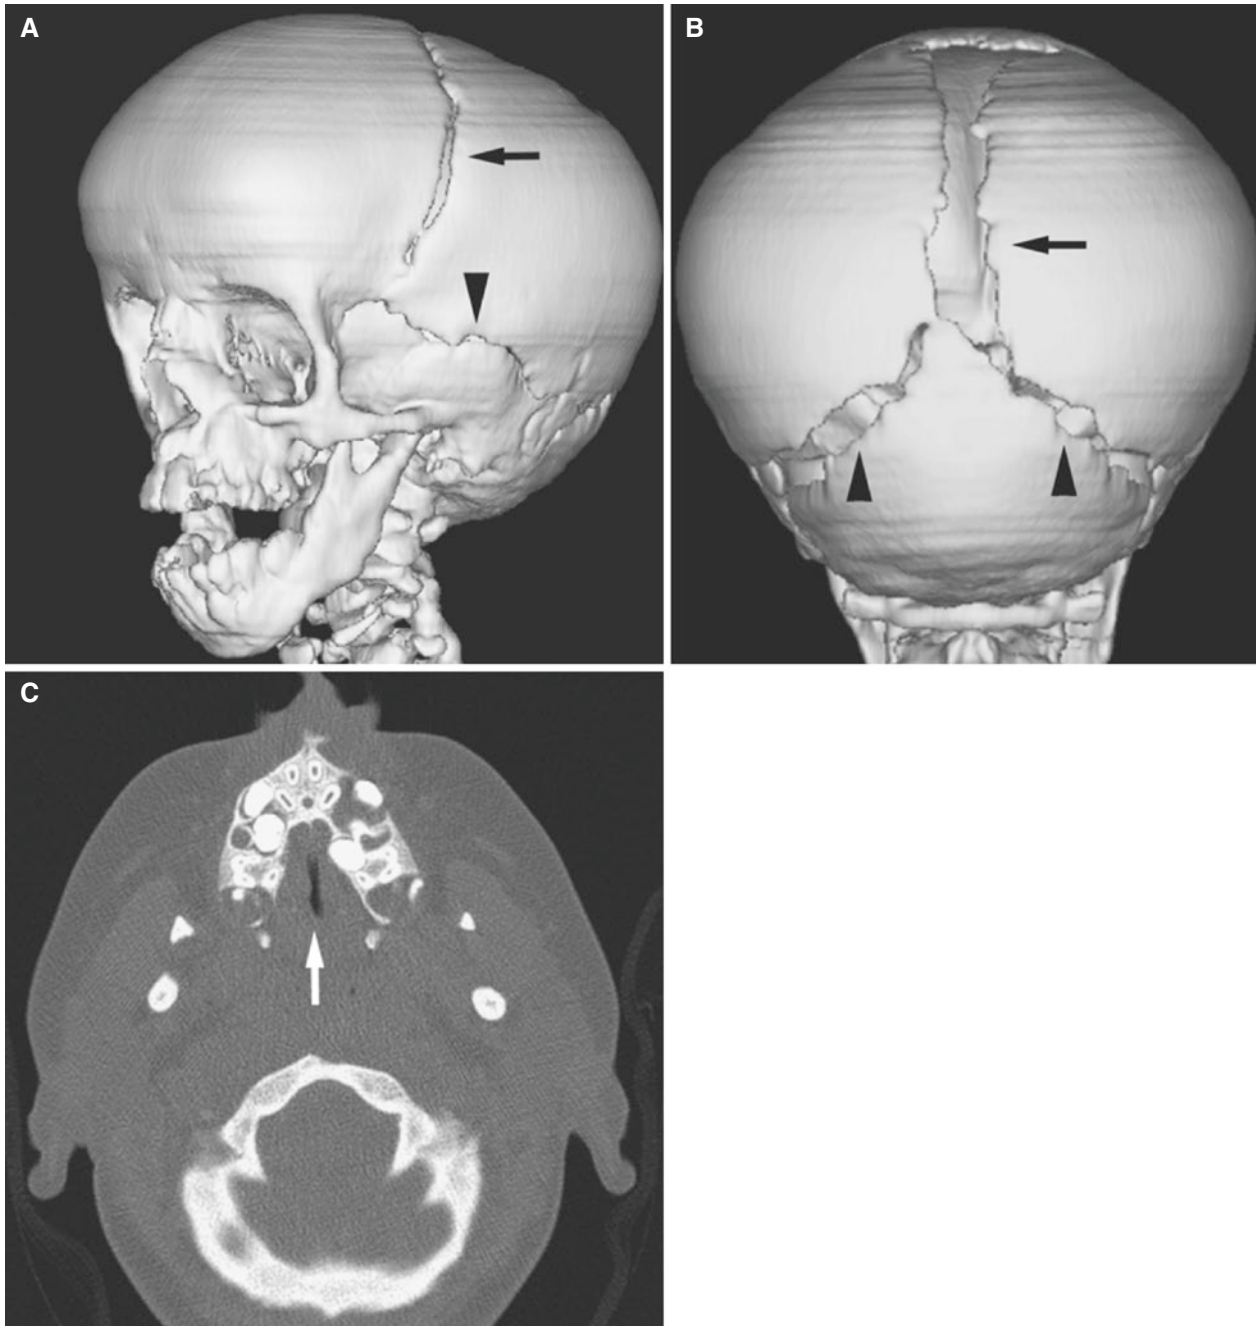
Pyknodysostosis; 9-year-old. (A) 3D CT image, oblique view, shows hypoplasia of the maxilla and mandible and open coronal suture (arrow) and squamosal suture (arrowhead). (B) 3D CT image, axial view, shows wide open sagittal suture (arrow), open anterior fontanelle, and open lambdoid sutures (arrowheads). (C) Axial CT image shows narrow, dense maxilla and crowded teeth (some with widened follicles); incisors almost in sagittal line (arrow)
